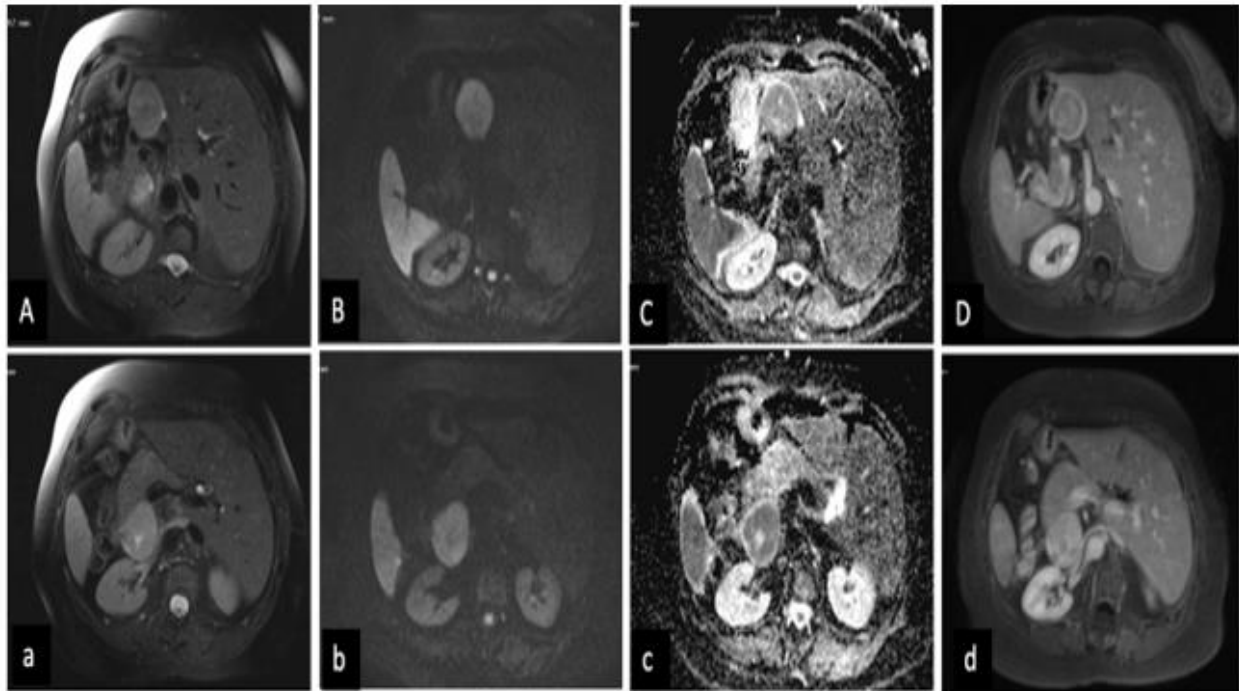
Images from magnetic resonance imaging (MRI). The peripheral solid component was hyperintense to the pancreatic parenchyma on T2-weighted imaging, and the central unenhanced portion was bright frank high signal indicating a cystic or necrotic component (A, a, D, d). Diffusion sequences showed a solid diffusion hypersignal component with decreased ADC (B, b, D, d).
